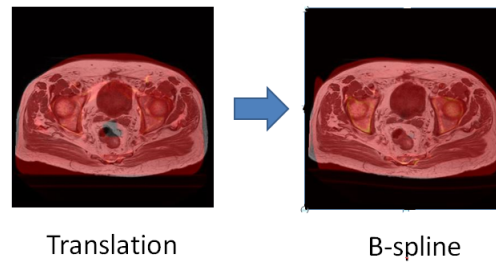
Inter-exam CT registration.
